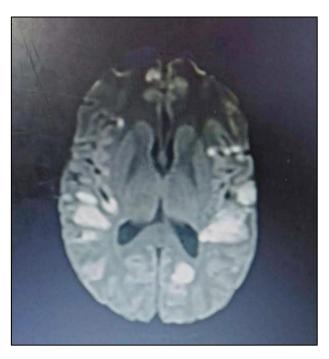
MRI brain in acute disseminated encephalomyelitis.
